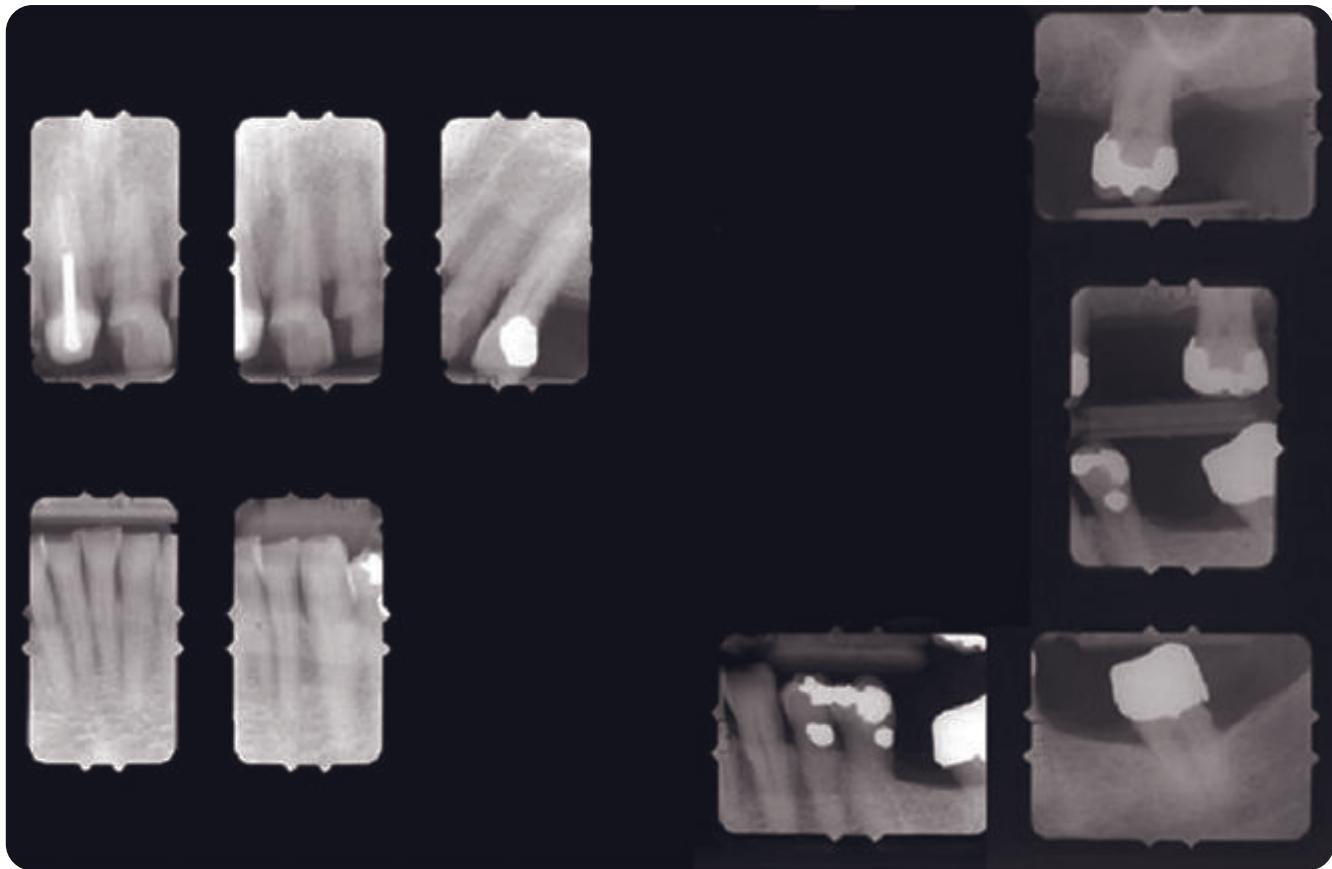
Preoperative radiographs, left side.
